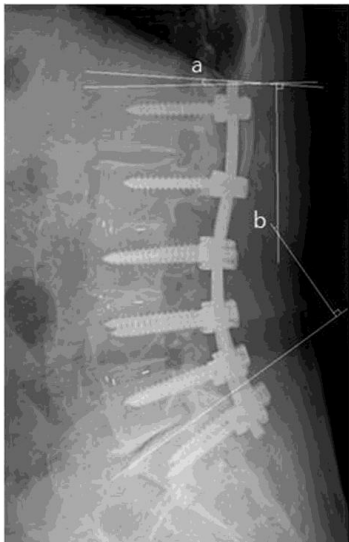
The sagittal angle measurement by Cobb's angle method on plain X-ray. The Adjacent Segmental Angle (ASA) was measured as total sum of intervertebral angles between flexion and extension lateral radiographs (a). To measure it, line along the end plate of adjacent vertebra body and line along the end plate of the most superior or inferior fused vertebra body were drawn. The Total Lumbar Lordotic Angle (TLA) was defined as the angle subtended by the superior end plate line of L1 and the superior end plate line of S1 (b)
